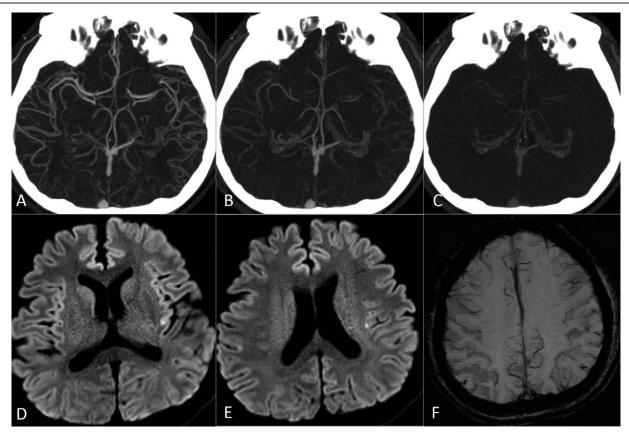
Follow-up multiphase computed tomography angiography and magnetic resonance imaging (MRI). A–C, Axial images of P1, P2, and P3. There is no contrast delay in left the middle cerebral artery territory. D–F, Follow-up MRI. Diffusion-weighted imaging scans (D, E) show focal acute infarction in the left external capsule, and susceptibility-weighted imaging scan (F) depicts that the migrated embolus in the left far distal branch has resolved.
